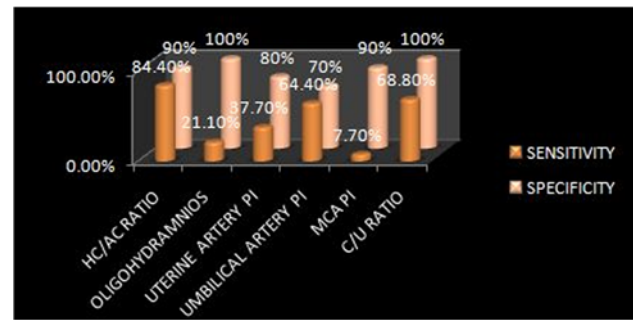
A comparison of sensitivities and specificities of various gray scale and doppler indices
